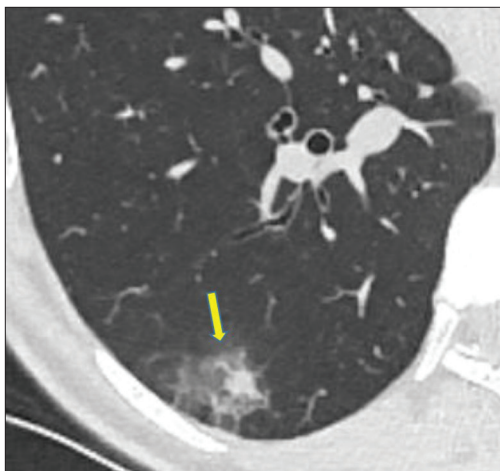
A 46-year-old male coronavirus disease 2019 patient presenting with fever with dry cough for 8 days. A computed tomography scan shows a solid nodule surrounded by a ground-glass halo in the right lower lobe (yellow arrow)
